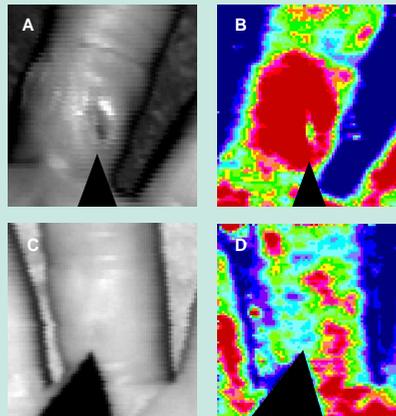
(A & B) laser Doppler image showing the black and white image of the ulcer (A) and perfusion map (B) at baseline. Reduced blood flow at the site of the ulcer can be clearly seen, surrounded by hyperaemia. (C & D) In the black and white image (C) the ulcer site can be seen to have healed. In the laser Doppler image the hyperaemia has reduced and the perfusion increased in the ulcer site (D).
